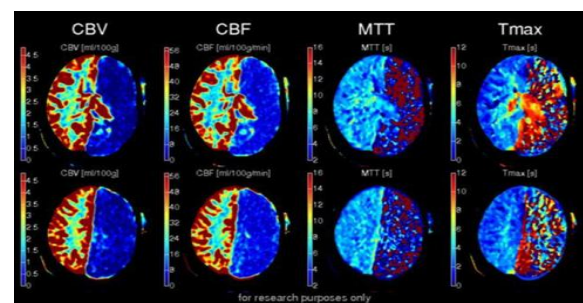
CT perfusion maps showing reduced cerebral blood flow and prolonged Tmax indicating ischemic penumbra surrounding the infarct core
